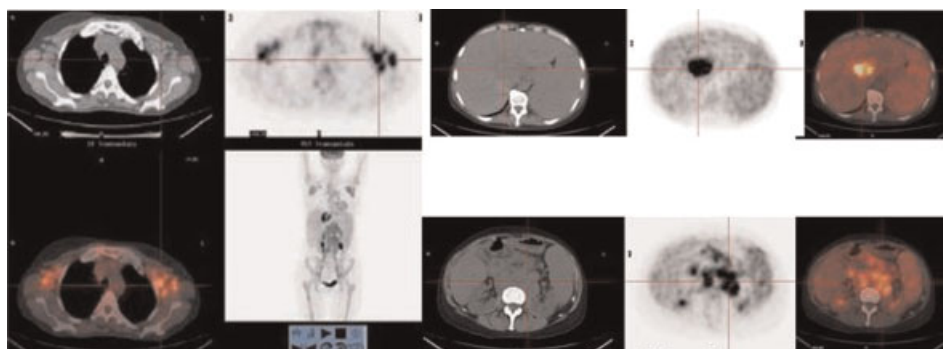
PET-CT. Patient with non-Hodgkin lymphoma referred for staging. Supra and infradiaphragmatic disseminated involvement was identified.
